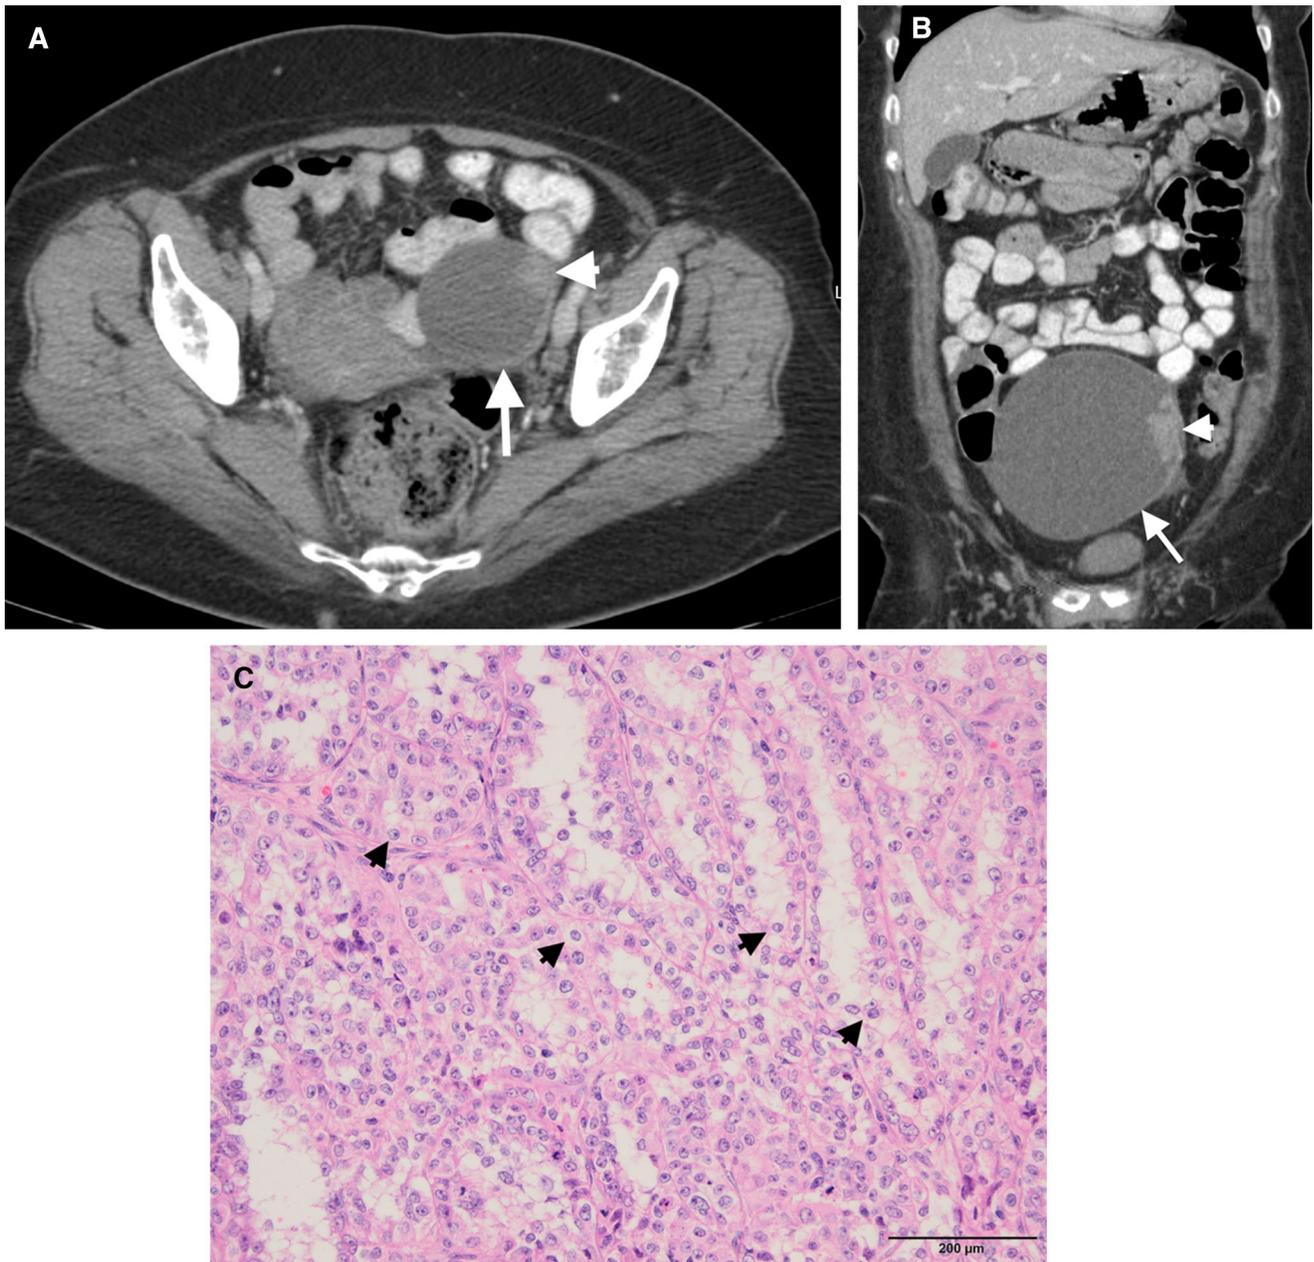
Fifty-two-year-old woman with a history of RCC treated with left radical nephrectomy 4 years before the current CT study. The patient was asymptomatic at the time of the presented CT study. A Axial post-contrast CT demonstrated a complex looking cystic mass (arrow), with mural enhancing nodule (arrowhead), in the left adnexa. The
